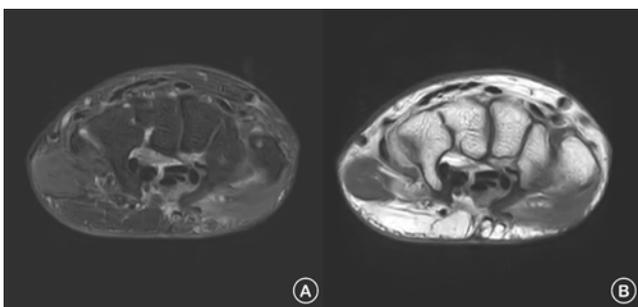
Axial MR images of the carpal tunnel (case 3). (A) T1-weighted image. (B) T2-weighted image. Images show volar subluxation of the flexor tendons, absence of the fifth FDS and FDP (flexor digitorum profundus) tendons, and diffuse tenosynovitis
